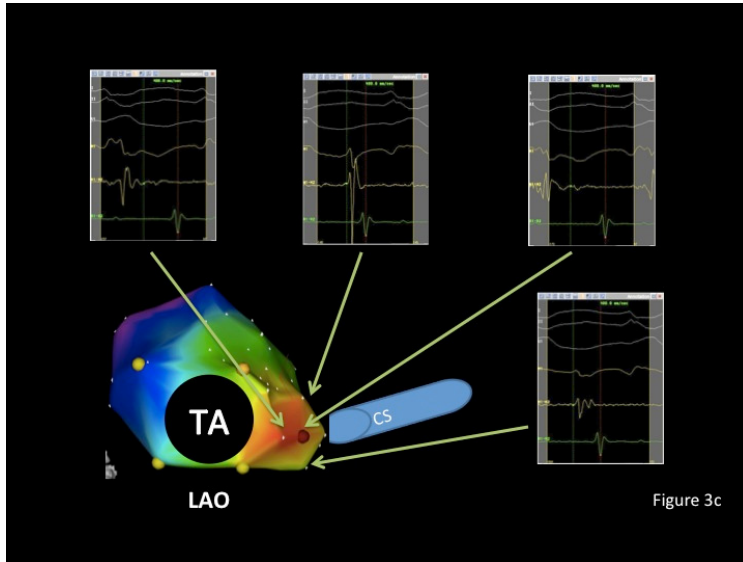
3D electroanatomical mapping (activation map) and endocardial electrograms during ectopic atrial tachycardias. Figure 10a. The ectopic atrial tachycardia originated from the lower CT. The right inferior electrograms show that mid-septum was activated later than the CS ostium. The left superior activation map shows the earliest activation spot with fragmented potentials on the ablation catheter and sharply negative unipolar electrogram. Figure 10b. The activation map shows the ectopic atrial tachycardia originating from non-septal TA (7 o'clock). The right superior electrograms show that mid-septum (posterior area of CS ostium) was activated later than the CS ostium. Figure 10c. The activation map shows an ectopic atrial tachycardia originating from the CS ostium.
